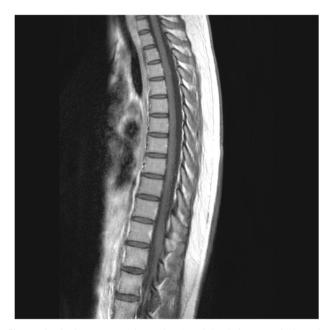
Sagittal contrast-enhanced T1-weighted image of thoracic spinal cord does not show any contrast-enhancing lesion
